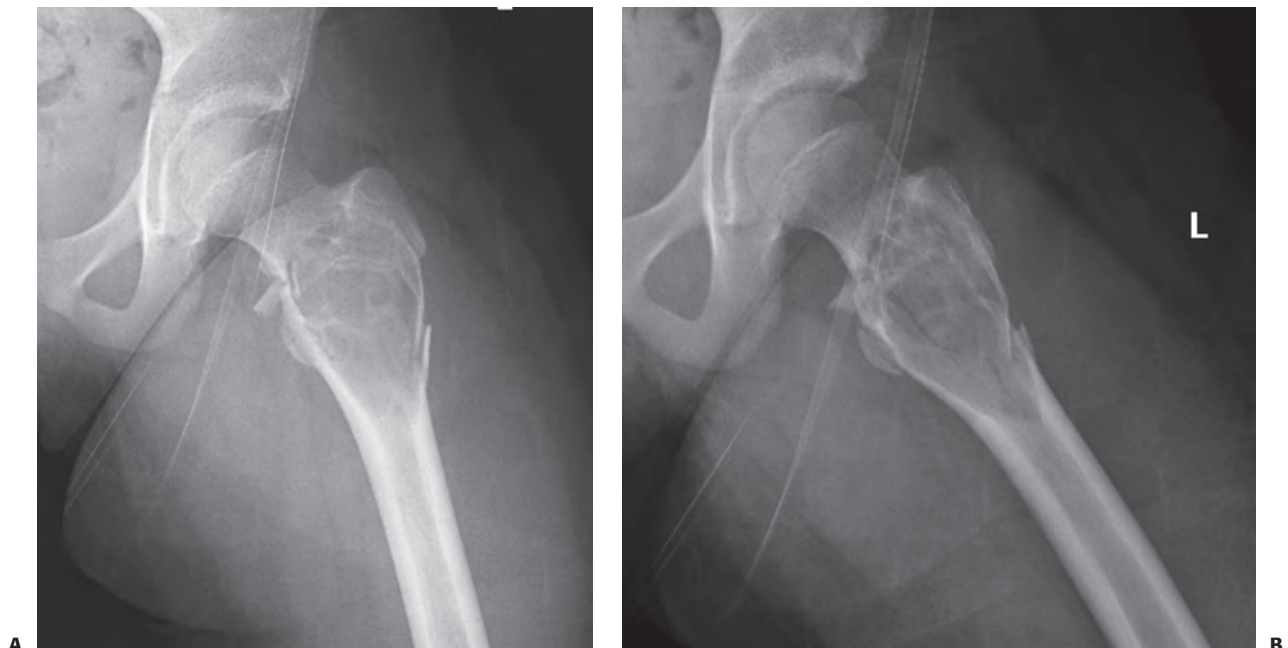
Anterior–posterior (A) and lateral (B) radiographs of a 12-year-old who suffered a fall and developed acute left hip pain and inability to ambulate. There is a pathologic fracture through a well-defined, lytic and loculated lesion in the proximal femur, with cortical thinning, no soft tissue mass or periosteal reaction.
